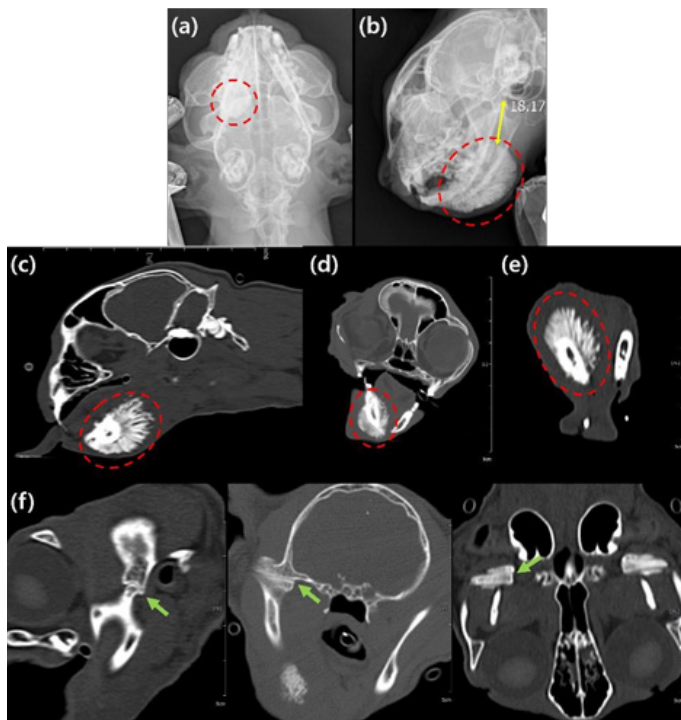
Radiography (a-b) and CT (c-f) reveal a spiculated periosteal reaction (“sunburst” type) on the right mandibular body (red dotted circle), 18.2 mm rostral to the TMJ (yellow arrow). The TMJ shows no evidence of involvement on CT (green arrow)
